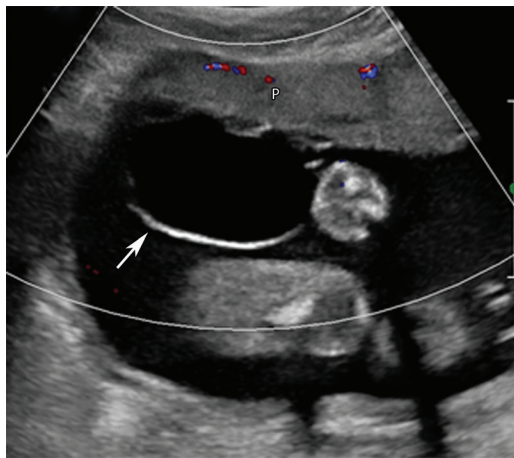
Chorionic plate cyst. Longitudinal color Doppler image at 23 weeks gestation shows a well-defined anechoic avascular structure (arrow) along the fetal surface of the placenta (P), which represents a chorionic plate cyst.
